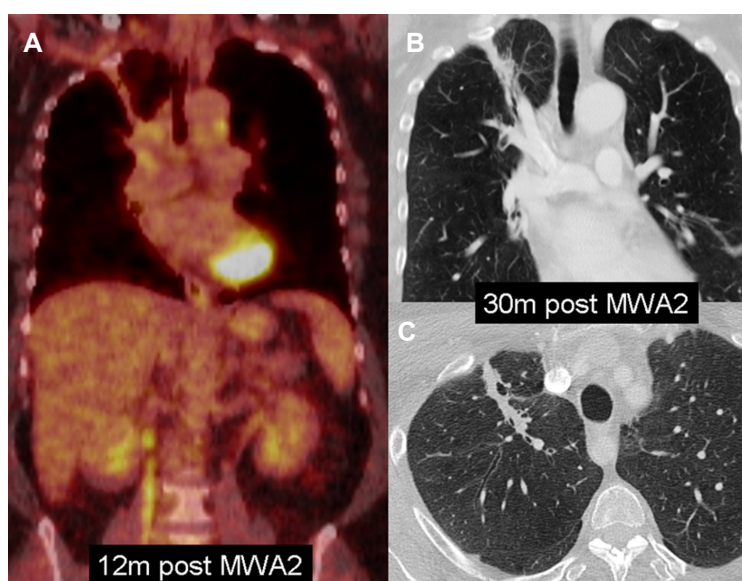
57-year-old female with RUL squamous cell carcinoma. A: Coronal FDG-PET/CT shows no residual FDG uptake at the RUL ablation site 12 months post re-ablation; B, C: coronal and axial CT scan lung windows 30 months post re-ablation shows band-like scarring/atelectasis at site of previous tumour. RUL: right upper lobe
